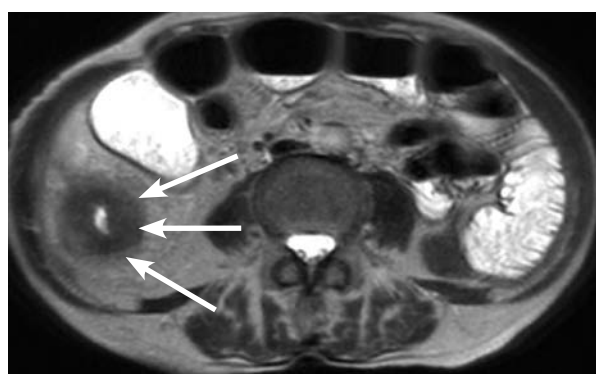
MRI. The arrows indicate the circular narrowing of the ascending colon up to 5 mm, the circular thickening of the wall up to 10 mm, and the compaction of the surrounding tissue
